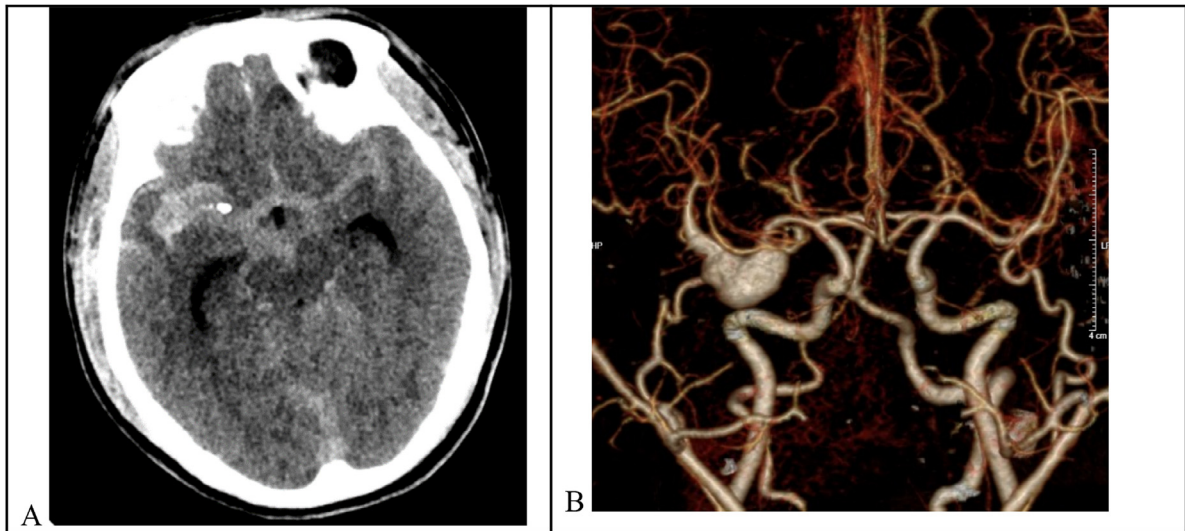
Computed tomography image of the brain, brain vessels at hospital admission
